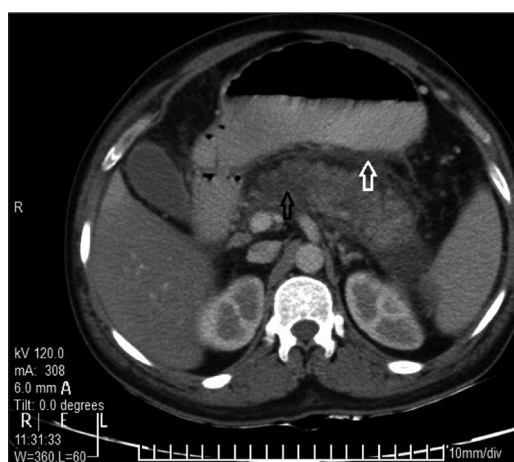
Contrast-enhanced computed tomography axial section reveals nonenhancing pancreatic parenchyma (black arrow) in the region of the head as well as the tail of pancreas suggestive of necrosis. Concomitant peripancreatic inflammatory changes co-exist (white arrow)
